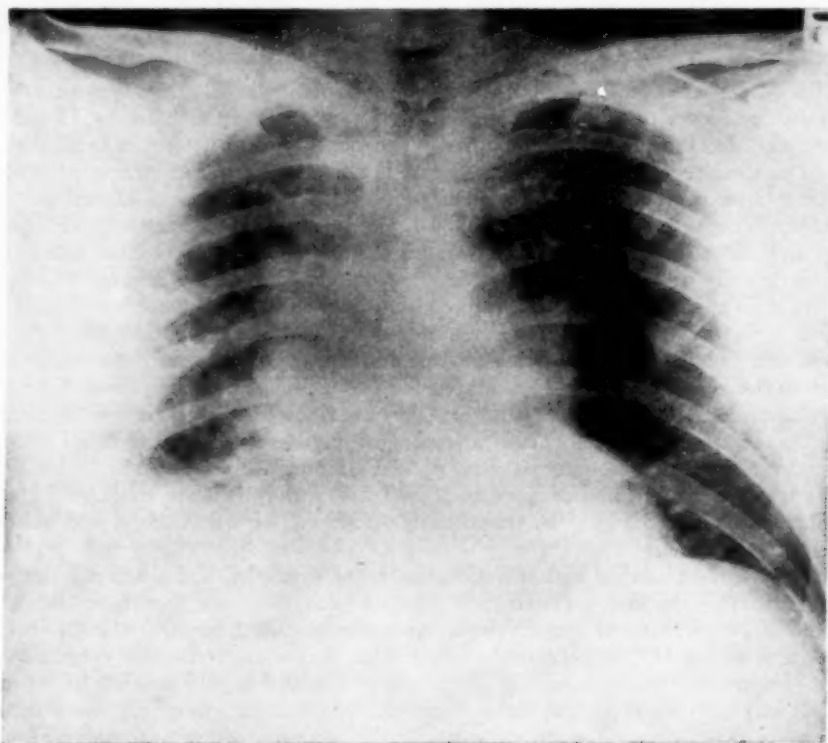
Roentgenogram showing pulmonary infiltration due to tularemia.
